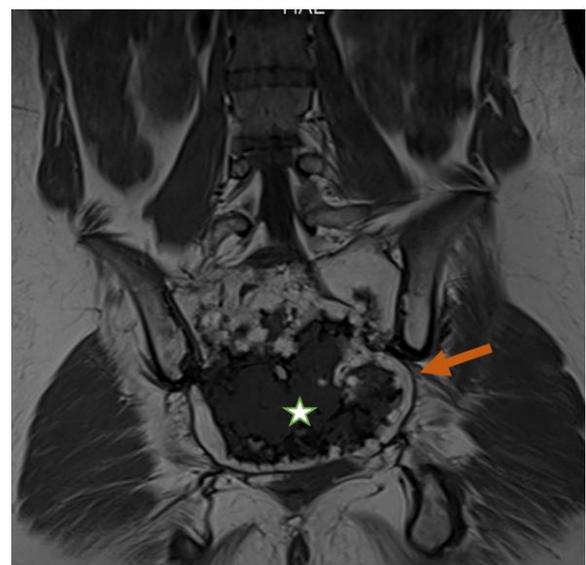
T1 weighted coronal MR images revealed a well-defined expansile destructive mass involving the sacrum (Asterix) with a heterogeneous hypo signal intensity on T1 and peripheric curvilinear area of high signal intensity (Orange arrow)
